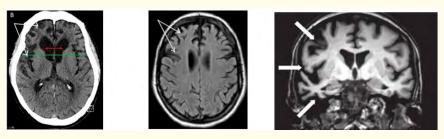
A: CT scan of the brain. B: Axial MRI T1. C: Coronal MRI T1.
